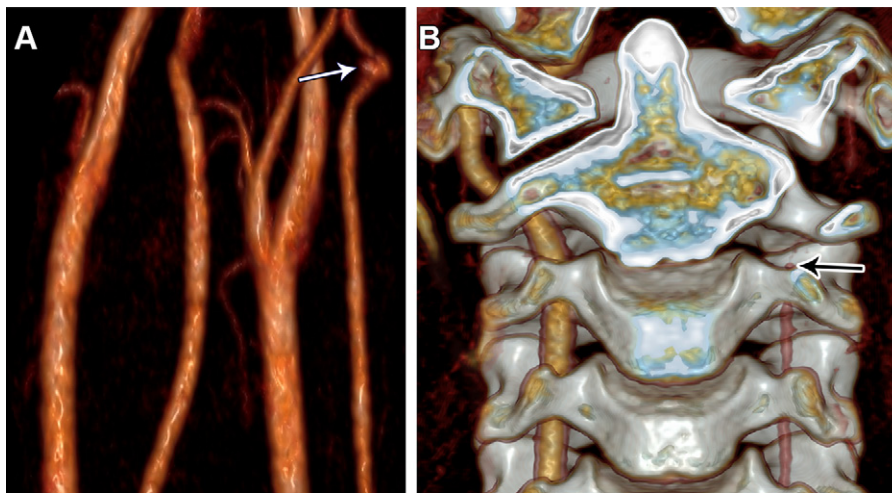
Left vertebral artery pseudoaneurysm that progressed to occlusion in a 12-year-old girl. (A) Oblique 3D volume-rendered TOF MR angiogram on day 0 shows a saccular pseudoaneurysm (arrow) in the left V3 segment, with preserved flow-related enhancement proximally. (B) Follow-up coronal volume-rendered CT angiogram on day 82 shows a new occlusion (arrow) near the V2-V3 junction and small caliber of the left vertebral artery.
